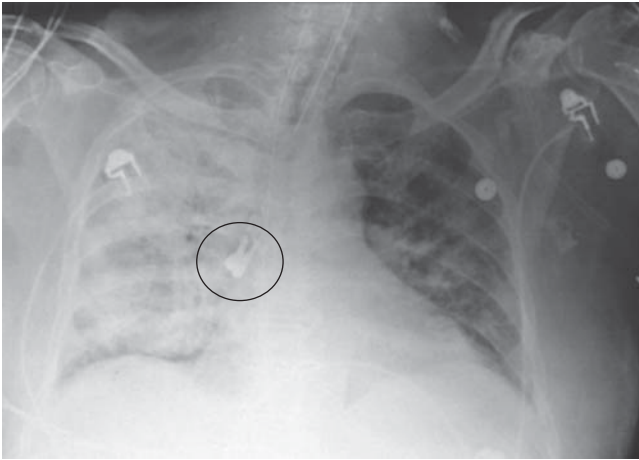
Chest radiograph showing an aspirated molar tooth in the right main bronchus of an intubated patient. Pneumonia in the right lung was also observed. (Reproduced, with permission, from Ostrinsky Y, Cohen Z. Tooth aspiration. *N Engl J Med.* 2006;354:e25. Copyright © Massachusetts Medical Society.)
